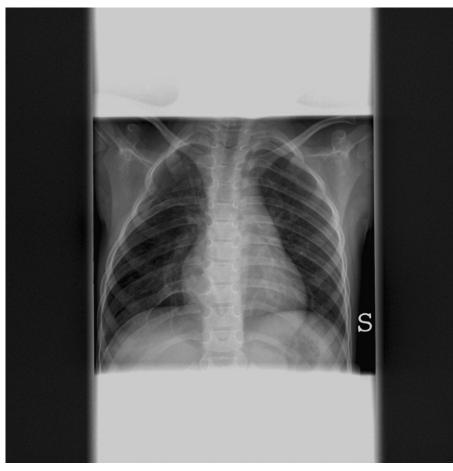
Chest x-ray. Four-year follow-up.
